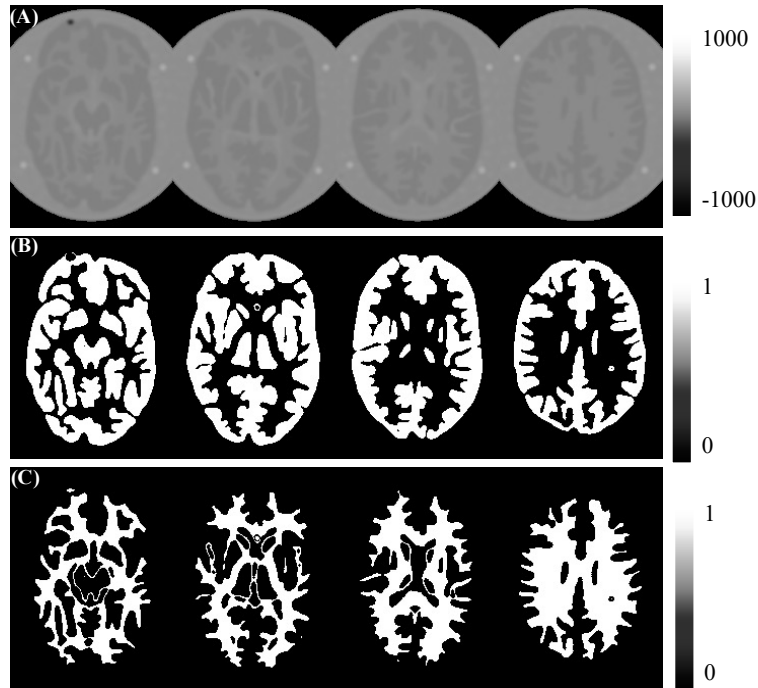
(A) CT image, (B) GM and (C) WM masks (binary images) obtained by segmenting (A) using in-house MATLAB scripts. Source: (The Author, 2021).
